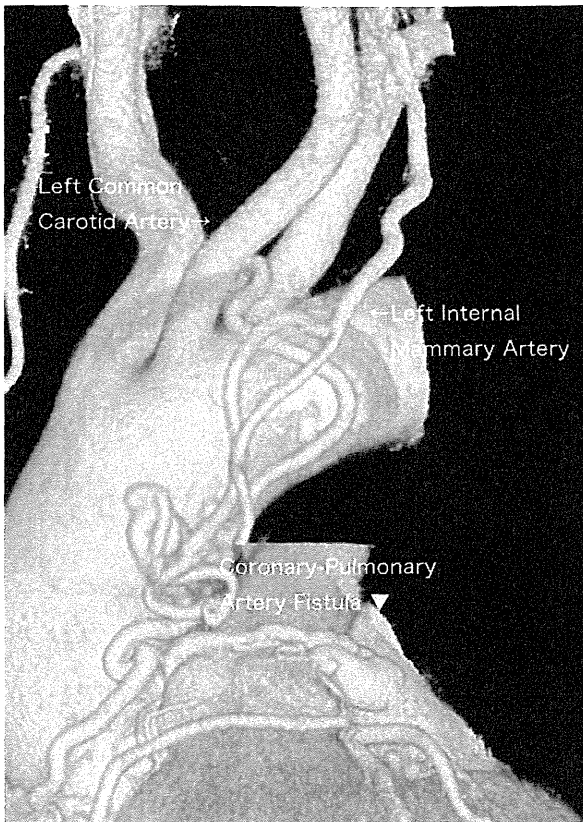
Multislice computed tomography. Multislice CT angiography showed two tortuous coronary artery fistulas, and revealed abnormal vessels that had connections with the right coronary artery, the left common carotid artery, and the left internal mammary artery
